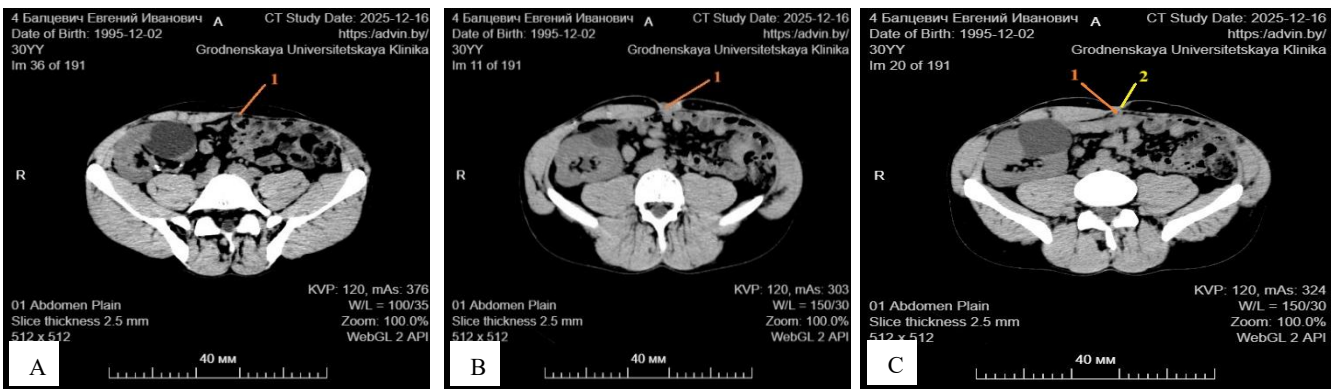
(A) abdominal CT showing the appendix (shown in arrow 1), (B) abdominal CT showing the appendix (shown in arrow 1) and skin (shown in arrow 2) and (C) abdominal CT showing the appendiculocutaneous fistula (shown in arrow 1).
